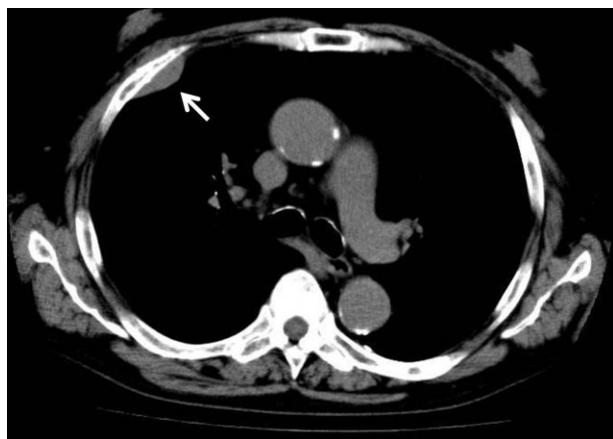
Chest computed tomography (CT) showing pleural thickening at the right 4th rib (arrow).
